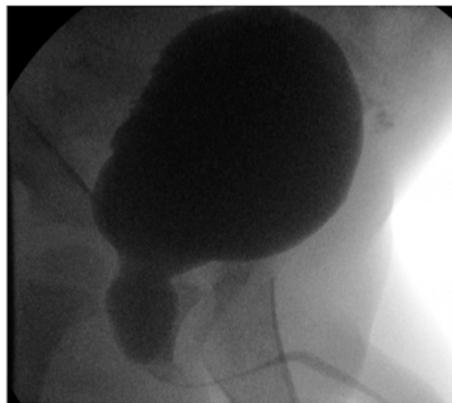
Examples of posterior urethral valves. Note possibility of high grade VUR (lower left) as well as small, trabeculated appearing bladder (lower right). The ultrasound (upper right) image demonstrates very thickened bladder with bilateral hydronephrosis that is evidence of bladder dysfunction.
